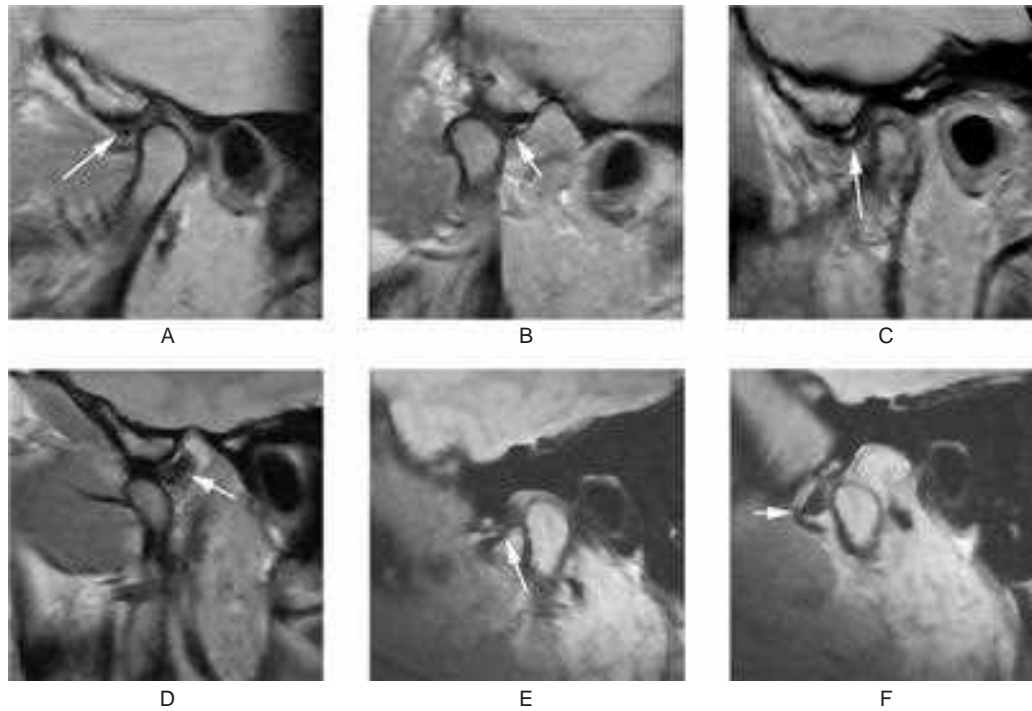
Magnetic resonance imaging of the temporomandibular joints.
